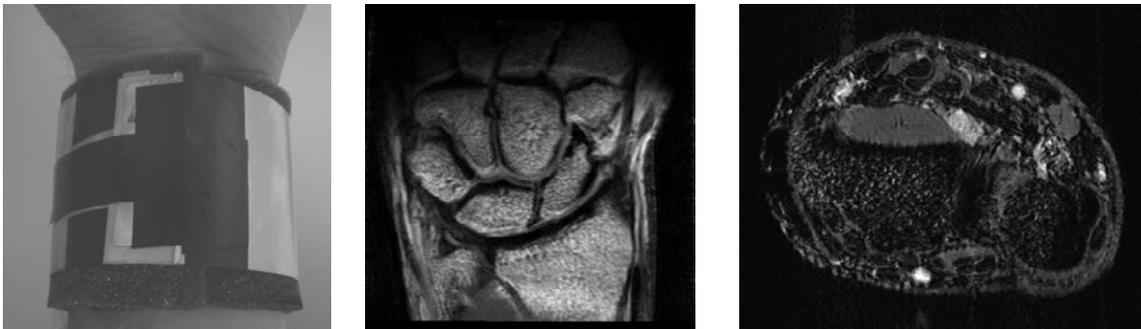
(left) Photograph of the flexible loop-gap resonator wrapped around the left wrist of a volunteer. (centre) Coronal T1-weighted spin-echo sequence acquired (TR/TE 1514/20, 228 x 180 data matrix zero filled to 480x480, fifteen 2 mm slices, flow compensated, 1 signal average). (right) One slice from a high-resolution 3D gradient echo data set (TR/TE 56/5.6 ms, data matrix 400x324x52, spatial resolution 0.18 x 0.18 x 0.4 mm, 1 signal average, 8 minutes data acquisition time).
